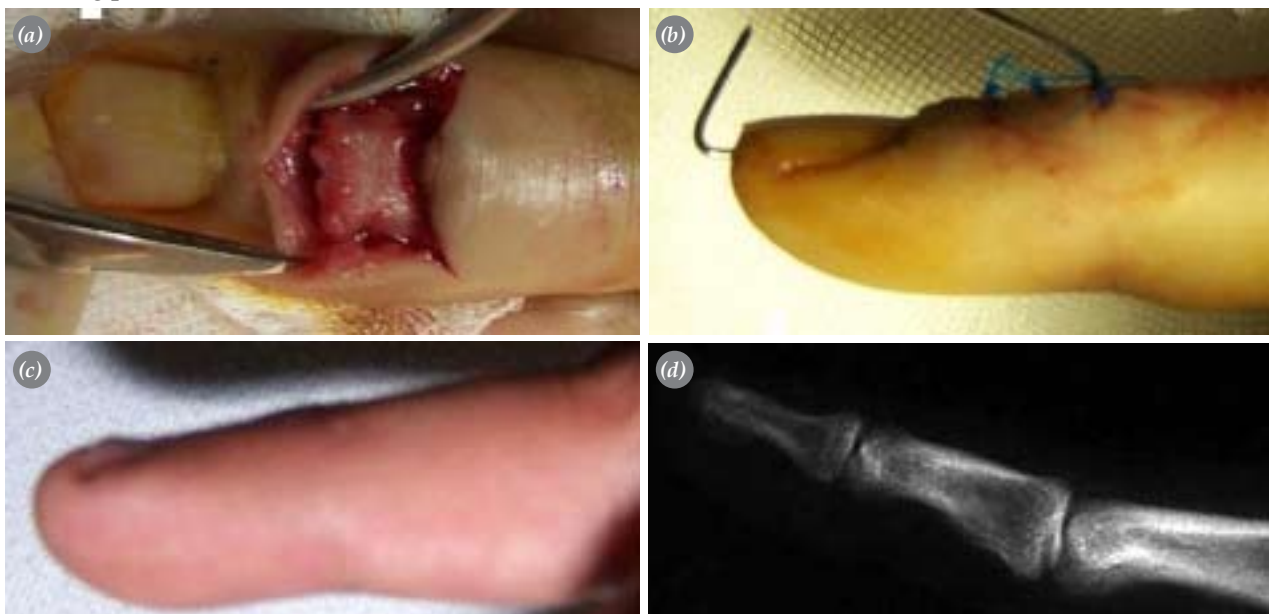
(a) Surgery of the patient. Intra-articular tissue and fracture ends were cleaned and prepared for fixation. (b) The figure of the finger and fixation material after surgery. (c) The clinical vision of the finger at the last control. The mallet pathology and extension insufficiency were improved. (d) The radiographical results of the finger at the last control. The fracture line was disappeared and healed.
